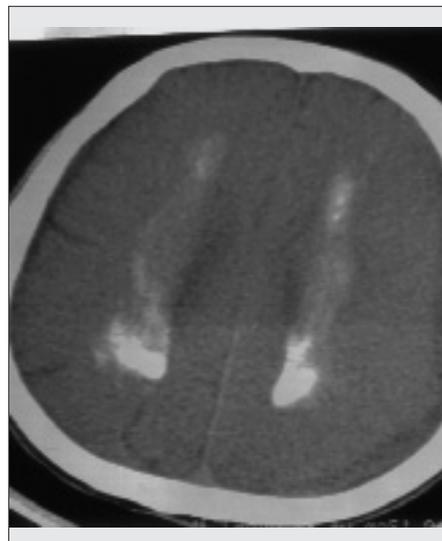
CT scan of our case
